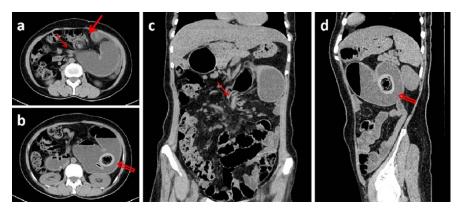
50-year-old female with internal hernia- CT.
